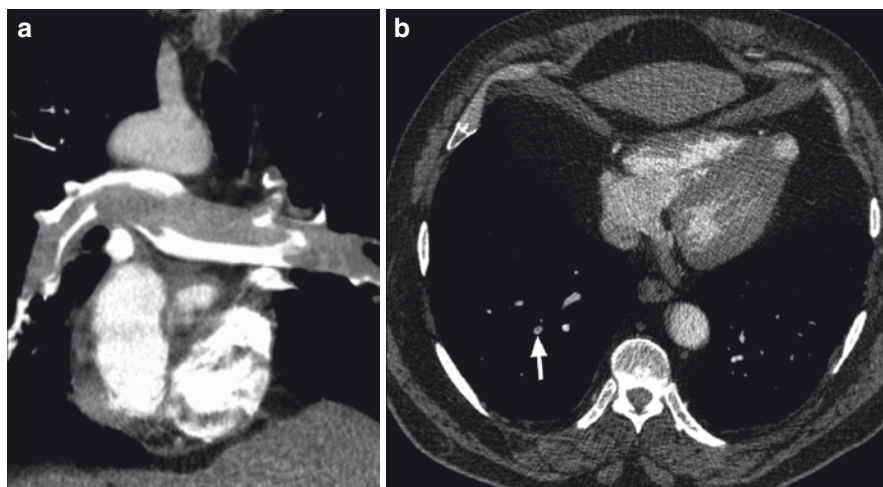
A saddle embolus is demonstrated in (a), a reconstructed image from a computed tomographic pulmonary angiogram (CTPA) examination. Less conspicuous is a small central filling defect (*white arrow*) within a subsegmental artery (b) on an axial CTPA image
